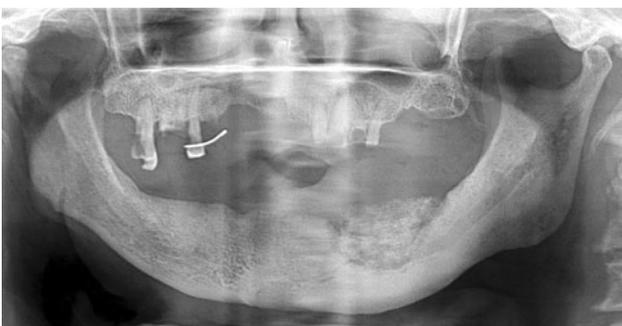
Digital panoramic radiograph showing a large bony sequestrum with a peripheral radiolucent rim and sclerosis surrounding the rim
